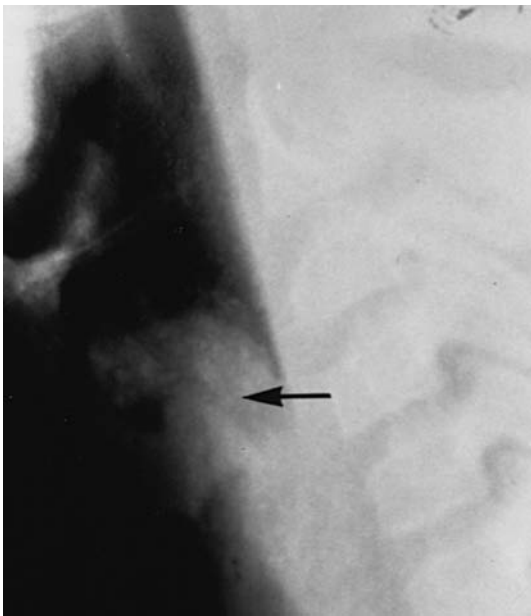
Lateral neck radiograph demonstrating soft-tissue density (arrow) at the level of larynx. Direct laryngoscopy revealed this to be papilloma.
